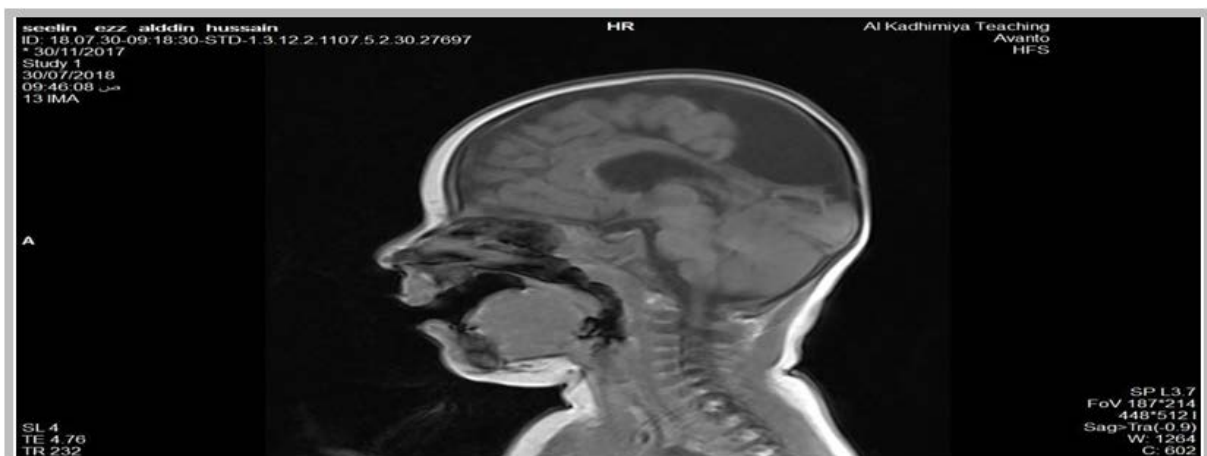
An 8 months old female patient, a midline sagittal image of T1 MRI shows marked loss of the parieto-occipital lobes with atrophy, and expansion of CSF spaces
